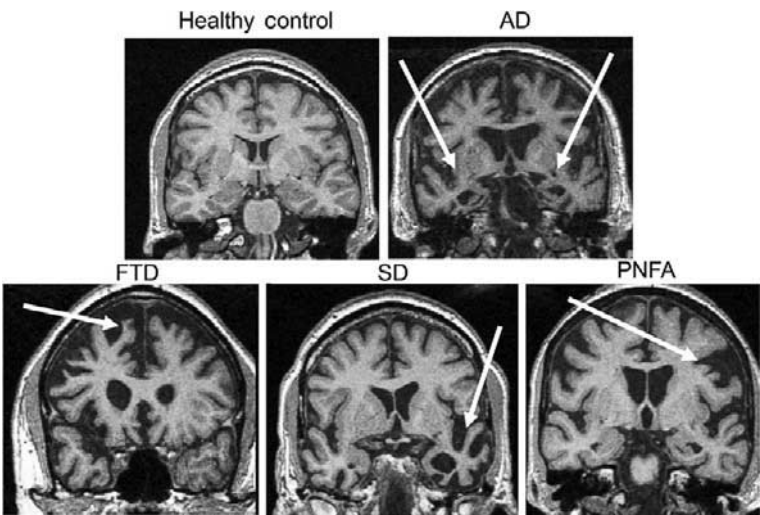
Atrophy patterns in dementia. Patients showing different patterns of atrophy in T₁-weighted MRI images of healthy age-matched control. AD, Alzheimer's disease; FTD, frontotemporal dementia; SD, semantic dementia; PNFA, progressive non-fluent aphasia.
